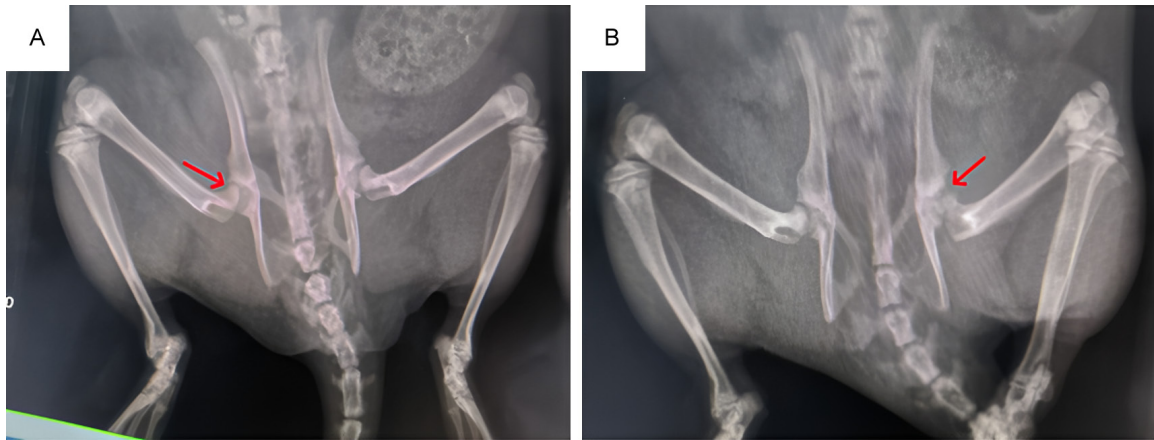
X-ray examination of the hip joint. A: The normal hip joint; B: The hip dislocation.
